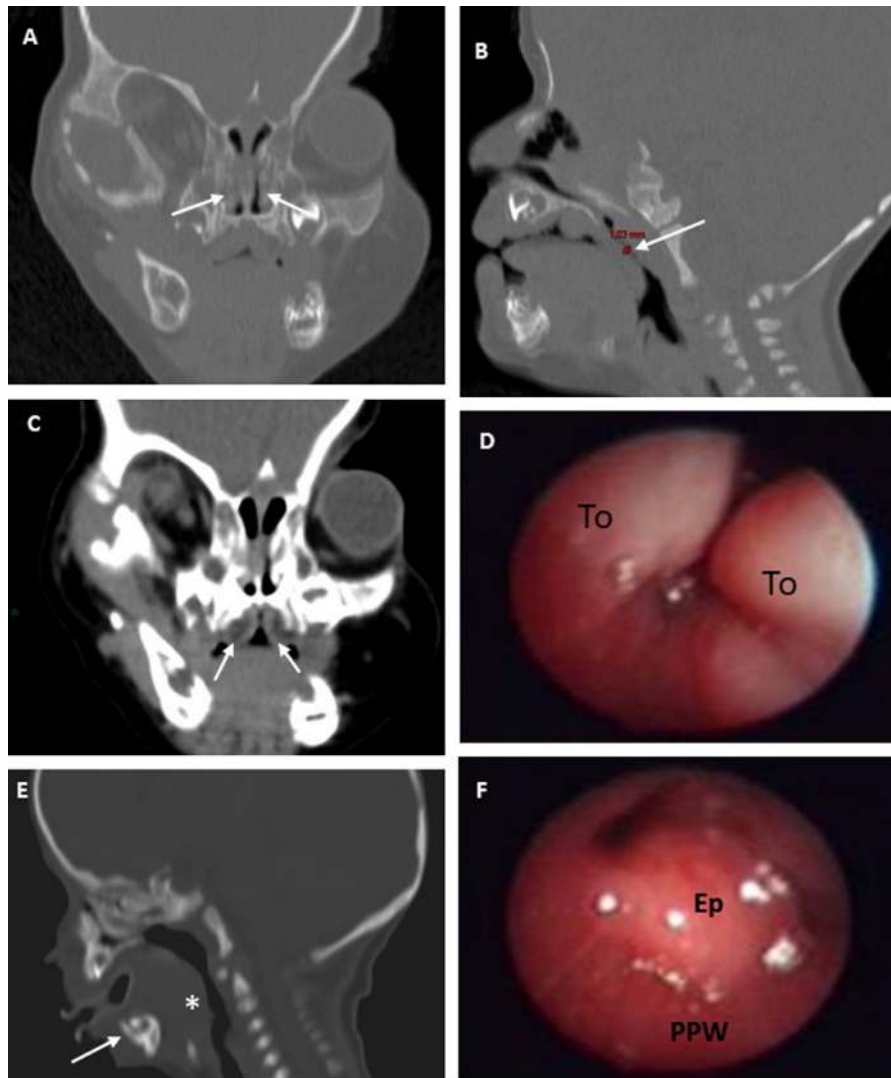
Main upper airway obstructive sites in craniostenosis. A. CT-scan, coronal view. 22 month-old child, Pfeiffer syndrome. Notice the narrowness of the nasal cavities (white arrows). B. CT-scan, sagittal view. Same patient as in A. Notice the narrowness of the rhinopharyngeal airway (white arrow). C. CT-scan, coronal view. 18 month-old child. Due to the narrowness of the oropharyngeal cavity, the palatine tonsils are in contact with each other despite their relatively small volume (white arrows). D. Drug-induced sleep endoscopy. Same patient as in C. Severe oropharyngeal obstruction by palatine tonsils (To). Underlying larynx and tongue base are not visible. E. CT-scan, sagittal view. 12 month-old patient, Crouzon syndrome. Insufficient mandibular growth with retrognathia (white arrow) and posterior displacement of the tongue basal (white arrow). F. Drug-induced sleep endoscopy. Same patient as in E. Due to insufficient mandibular growth and retrognathia, the tongue base and the epiglottis (Ep) are in a posterior position. Subsequently, the epiglottis is in contact with the posterior pharyngeal wall (PPW), and the oropharynx is severely obstructed. Underlying vocal folds and upper esophageal end are not visible.
